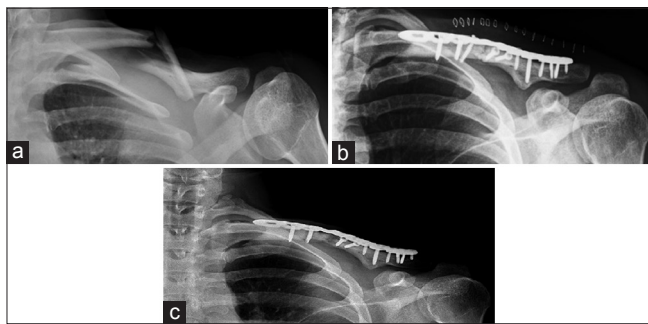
Preoperative anterior-posterior radiograph showing the comminuted midshaft fracture of the left clavicle, (a) Postoperative anterior-posterior radiograph showing the anatomical reduction of the left clavicle fracture with fixation using a plate and screws, (b) Preoperative anterior-posterior radiograph before the plate removal, indicating potential nonunion of the fracture site. A cortical screw in the proximal fragment was removed previously under local anesthesia owing to loosening and skin impingement (c)
